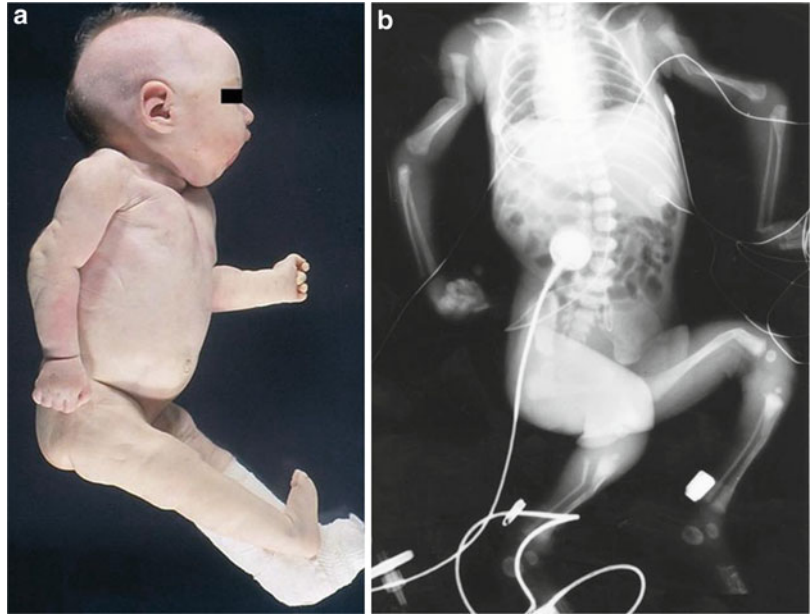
(a, b) A neonate with fetal akinesia sequence showing micrognathia and multiple contractures. The radiograph showed gracile ribs and fractures at mid-diaphyses of humeri
